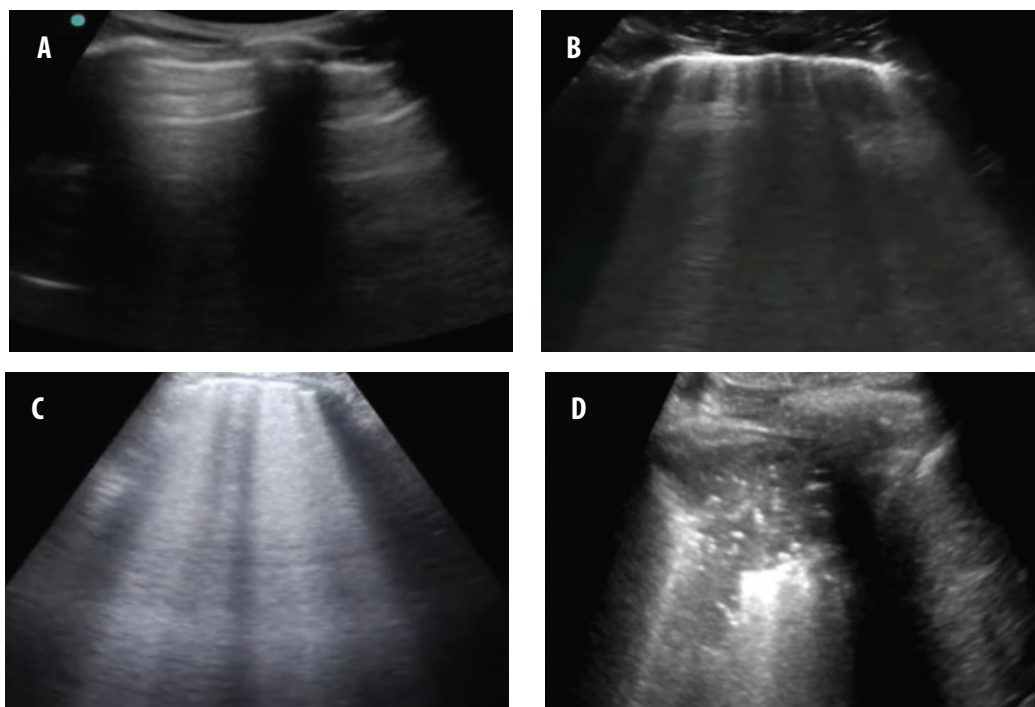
Ultrasonographic findings of pulmonary ultrasound: Figure 2A. Presence of A-lines showing good aeration of the lung scored with 0 points; Figure 2B. Presence of B-lines scored with 1 point; Figure 2C. Presence of multiple B-lines with their confluence scored with 2 points and Figure 2D. Pulmonary consolidation scored with 3 points according to LUSS.
